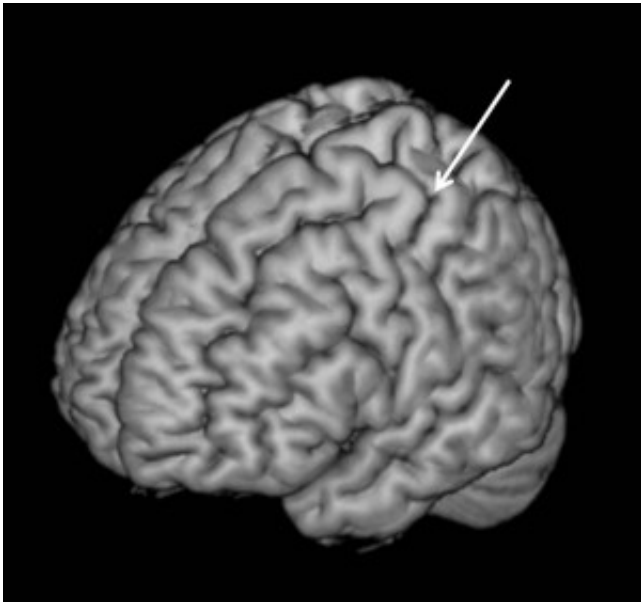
The location of the sensorimotor area in the brain. MRI: MNI template brain (MRIcron, <http://www.mccauslandcenter.sc.edu/micro/micron/>).
